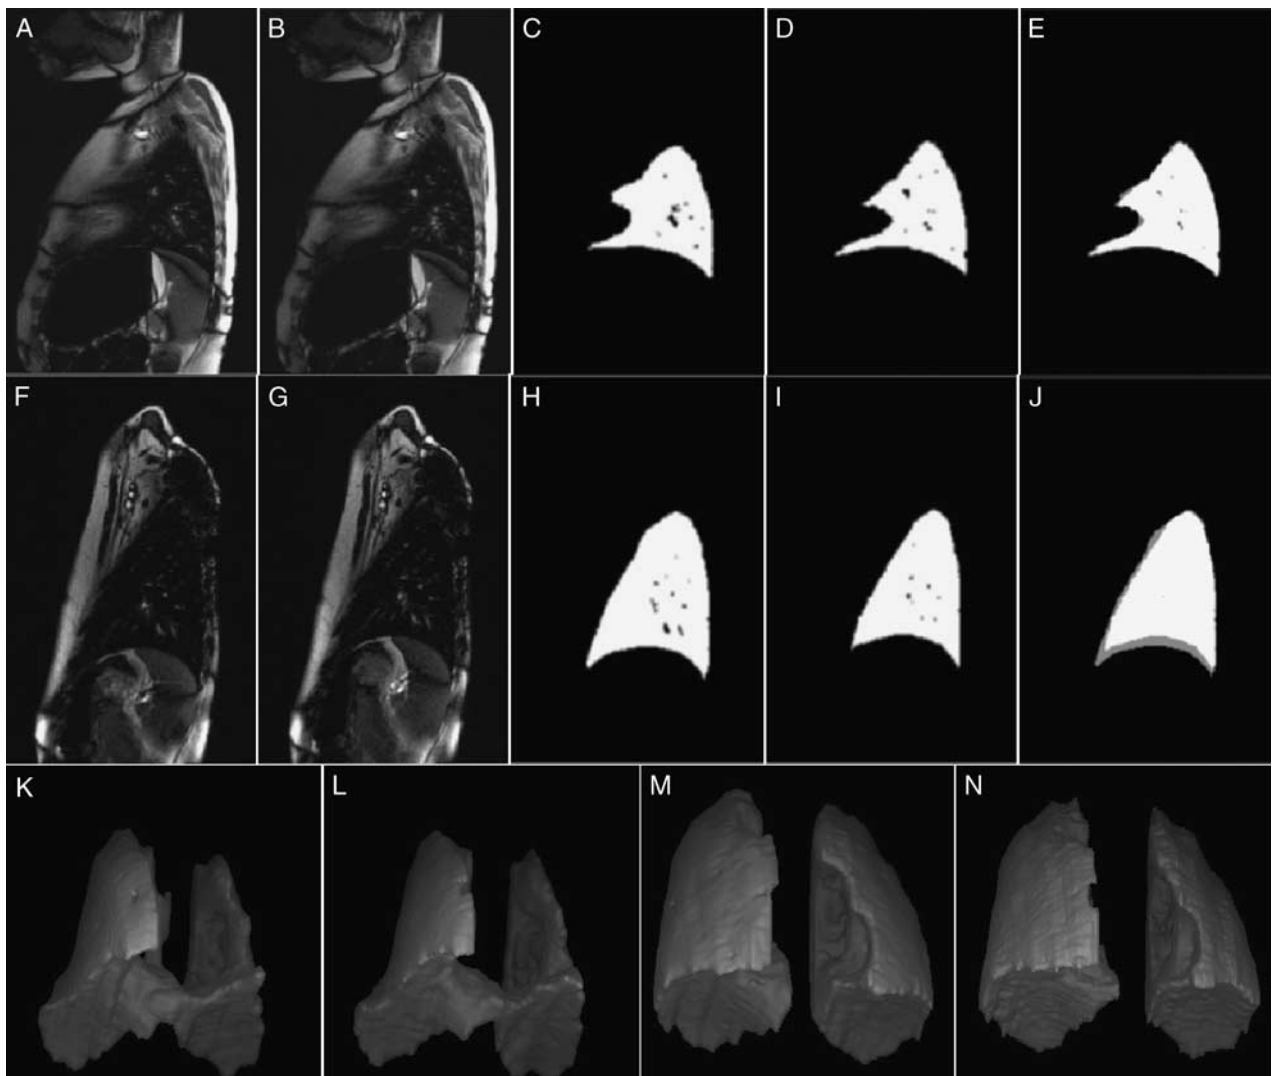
Row 1: (A and B) A single representative sagittal True-FISP dMRI slice through right lung from the preoperative 4D constructed image of a thoracic insufficiency syndrome patient in end-inspiration and end-expiration, respectively (all analyses are carried out on full-volume images and not just on slices). C and D, Segmentations of the slices in (A) and (B), respectively. E, The 2 segmentations in (C) and (D) superimposed (where the segmentation for end-inspiration is shown a little darker than that for end-expiration) to show lung motion in the slice plane. Clearly, there is very little motion. Row 2: (F–J) Same as row 1 but from the postoperative dMRI data set of this patient approximately at the same anatomic slice location. Increased chest wall and diaphragmatic motion can be clearly seen. Row 3: 3D renditions of the lungs at end-inspiration (K) and end-expiration (L) for the preoperative condition, and (M, N) similarly for the postoperative condition. Note the relative increase in lung volumes following surgical intervention. dMRI indicates dynamic magnetic resonance imaging.
